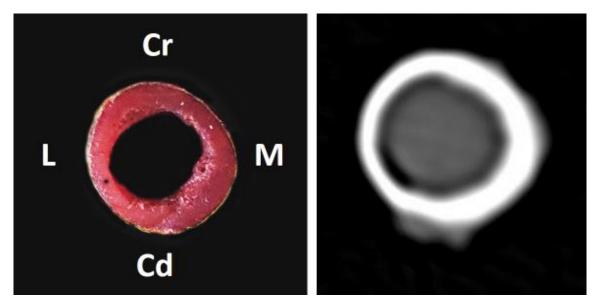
The cross-sectional view of right femur (photograph and CT scan)
